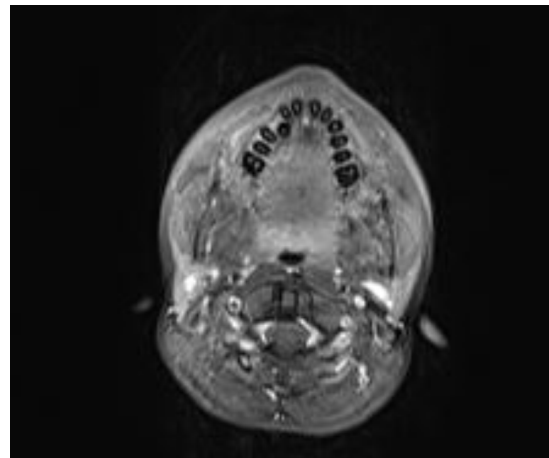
MRI observed normal
